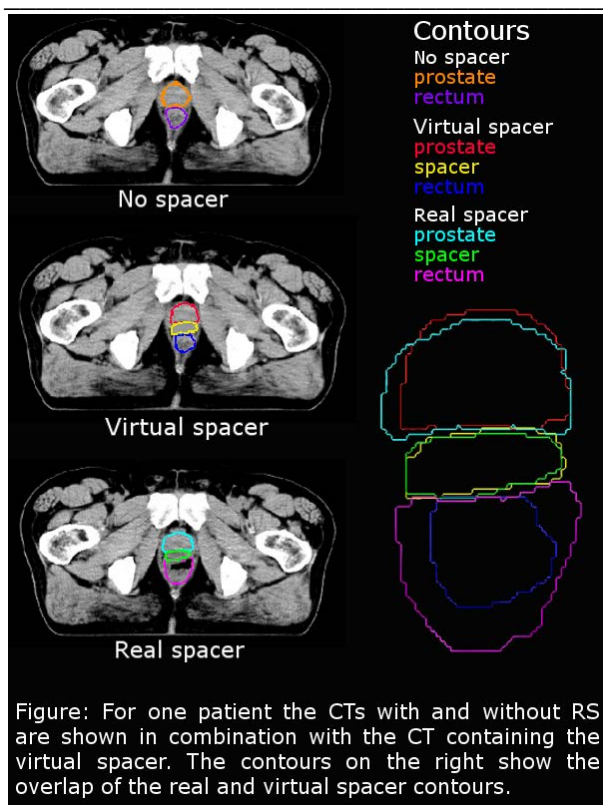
For one patient the CTs with and without RS are shown in combination with the CT containing the virtual spacer. The contours on the right show the overlap of the real and virtual spacer contours.
